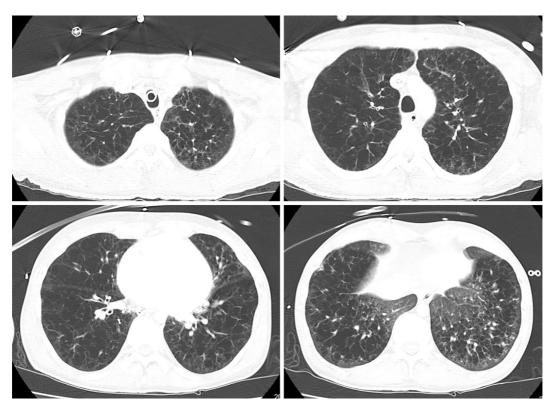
High-resolution computed tomography (HRCT) of the thorax. Diffuse low attenuation areas and bullas are seen throughout the lung fields.
